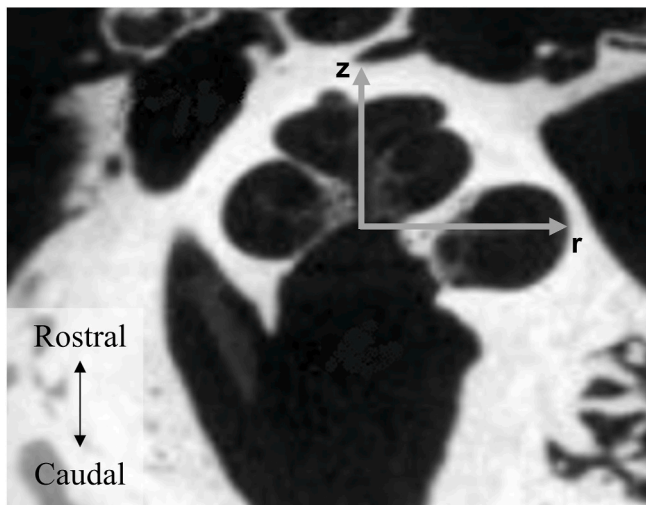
Mid-modiolar view of the left human cochlea (μ CT image) at an unspecified angle showing the z-axis aligned with the modiulus and the radius r to the lateral point of the lower basal turn.
